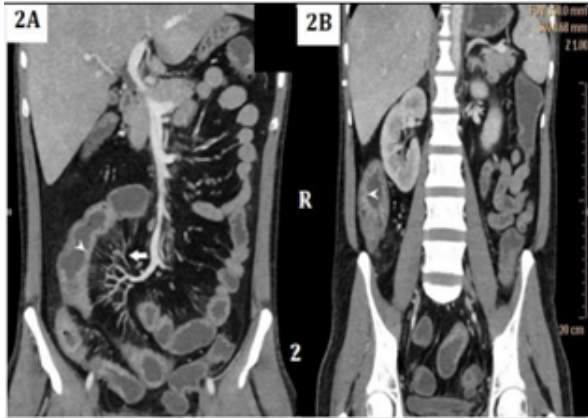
Coronal CT enterography images (2A & 2B) demonstrate prominence of the vasa recta, producing the characteristic comb sign (arrows), along with perienteric fat stranding along the mesenteric aspect of the thickened bowel (arrowhead in 2A). Image 2B further shows mural hyperenhancement with a layered (stratified) enhancement pattern (arrowhead), findings consistent with Crohn's disease.
